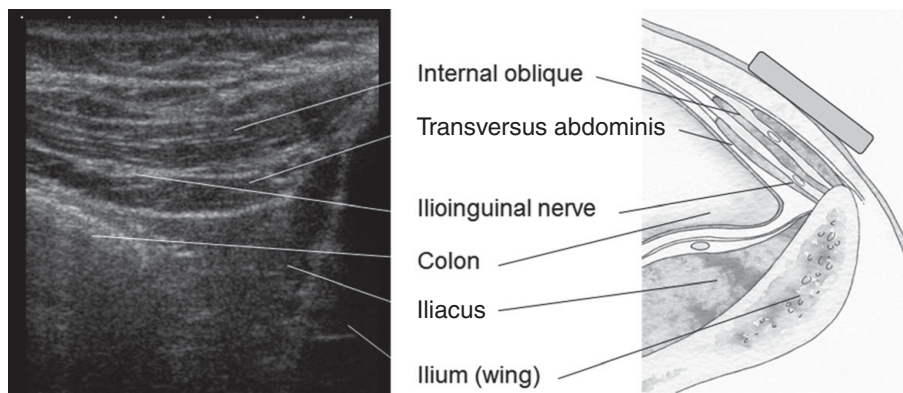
Iliioinguinal nerve anatomy. Reproduced with permission from Arthurs G, Nicholls B (eds.) 2016. *Ultrasound in Anesthesia, Critical Care, and Pain Management*. Cambridge, UK: Cambridge University Press
